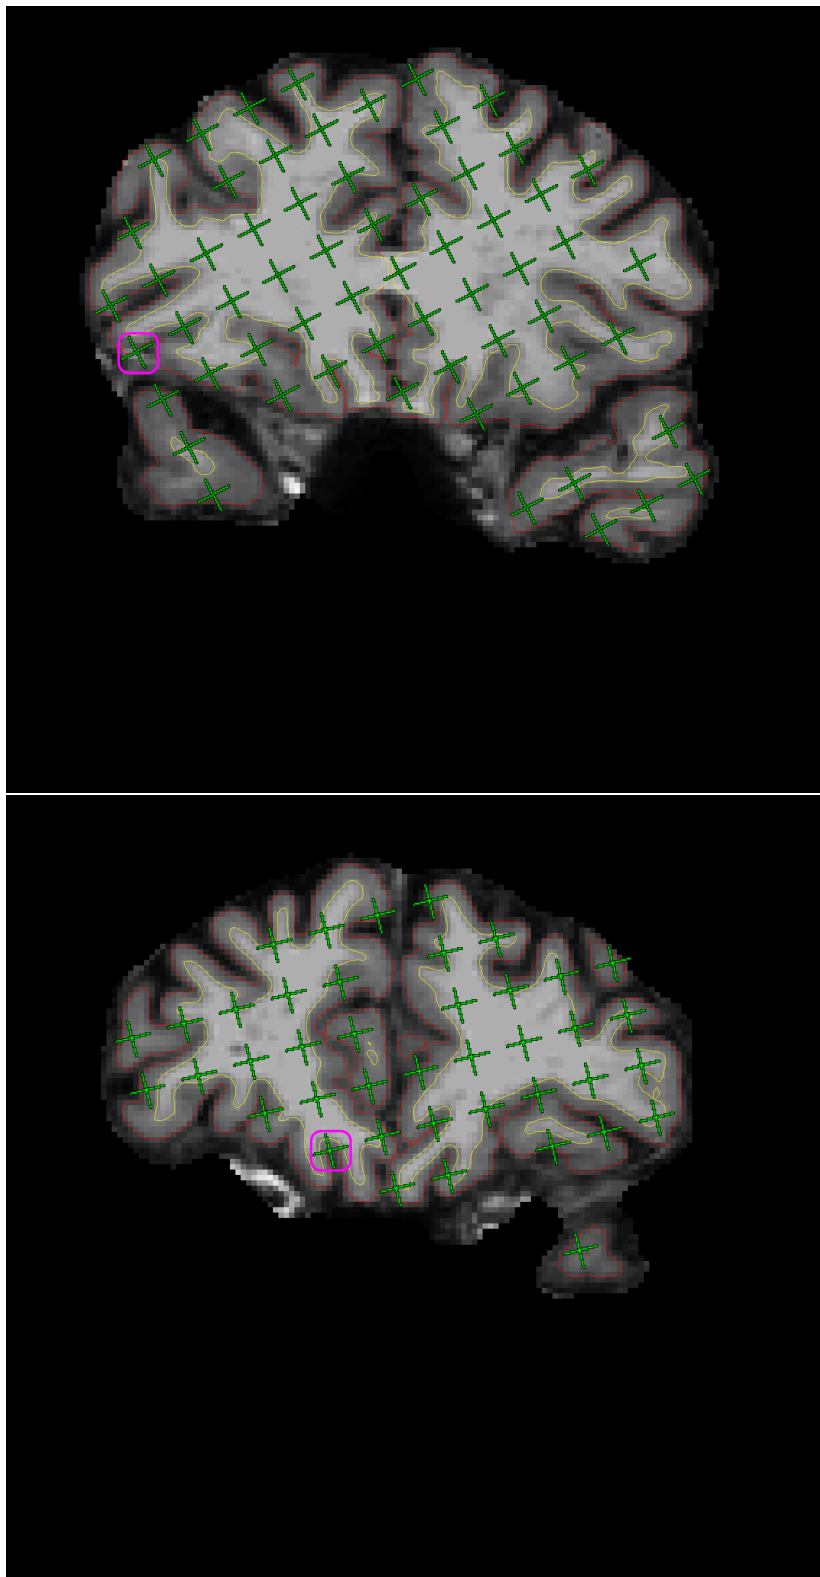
On the 13th and 14th slices of one brain MR image in the coronal view, counted test points (green) hitting the cerebrum (excluding ventricles) are overlaid onto pial profiles (red lines) segmented by FREESURFER. Rounded rectangles (pink, racetrack-like) mark the test points hitting exactly on the grey matter boundaries (red lines).
